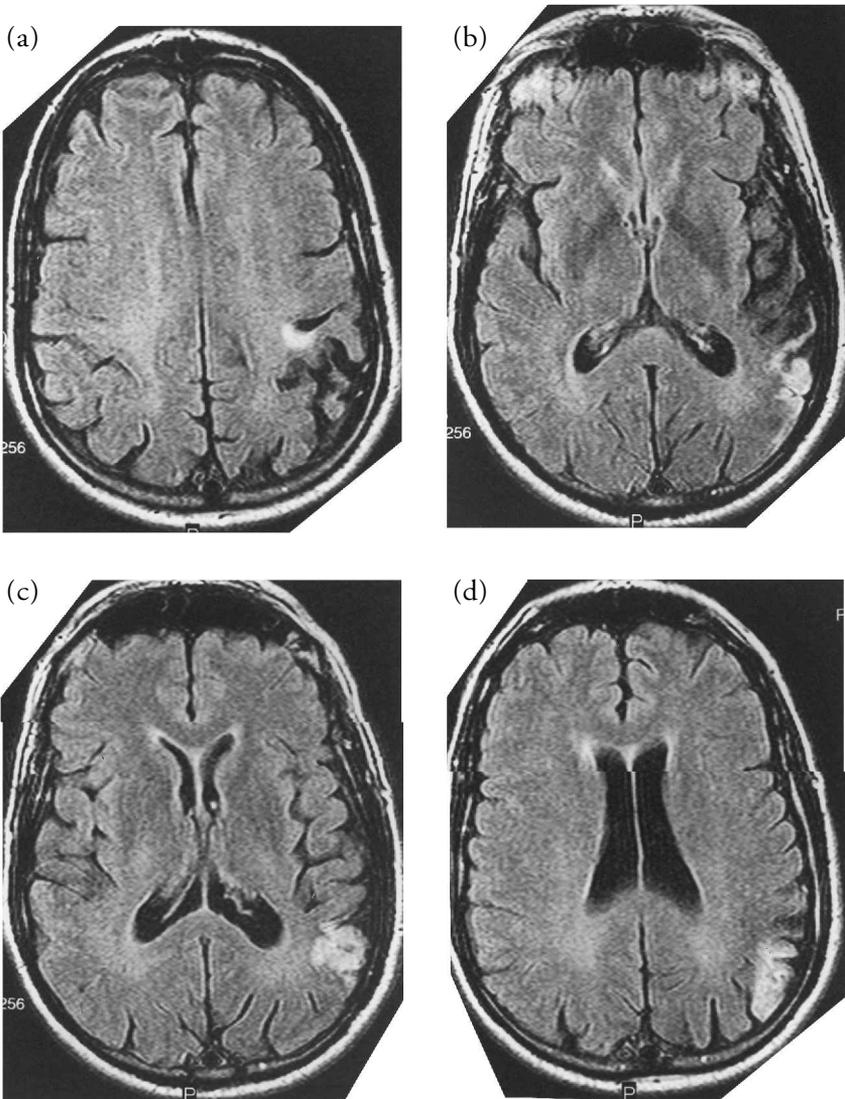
Axial view. Axial FLAIR (fluid attenuated inversion recovery images) sequences show gyriform increased signal along the angular gyrus.
